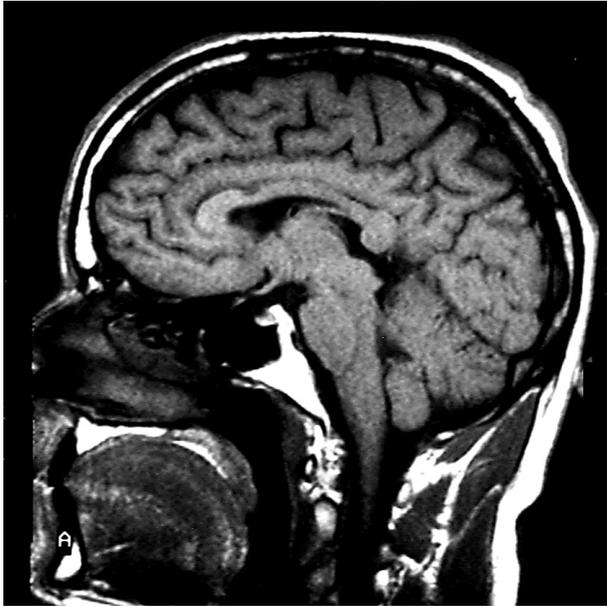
Inverted MRI showing components of the corpus callosum and their relationships to individual cerebral lobes, gyri and the septum pellucidum
